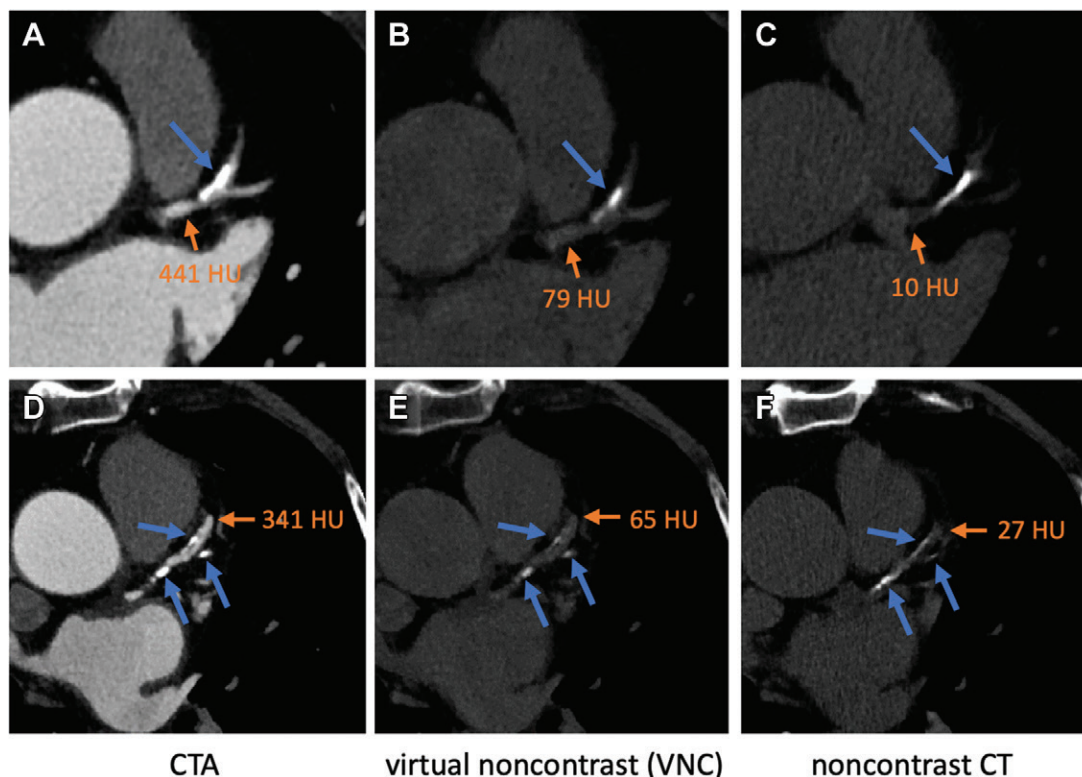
(A–F) Calcifications (blue arrows) are shown on CT angiography (CTA), VNC CT, and noncontrast CT scans in two patients in training set. Appearance of calcifications on VNC CT scans (B, E) and noncontrast CT scans (C, F) is similar and can be easily obtained using predefined threshold of 130 HU, as coronary artery attenuation (orange arrow in B, C, E, and F) is clearly smaller than 130 HU. However, obtaining coronary artery calcium (CAC) region and estimating corresponding CAC score by means of CTA (A, D) can be challenging because of variable attenuation of contrast-enhanced artery.
